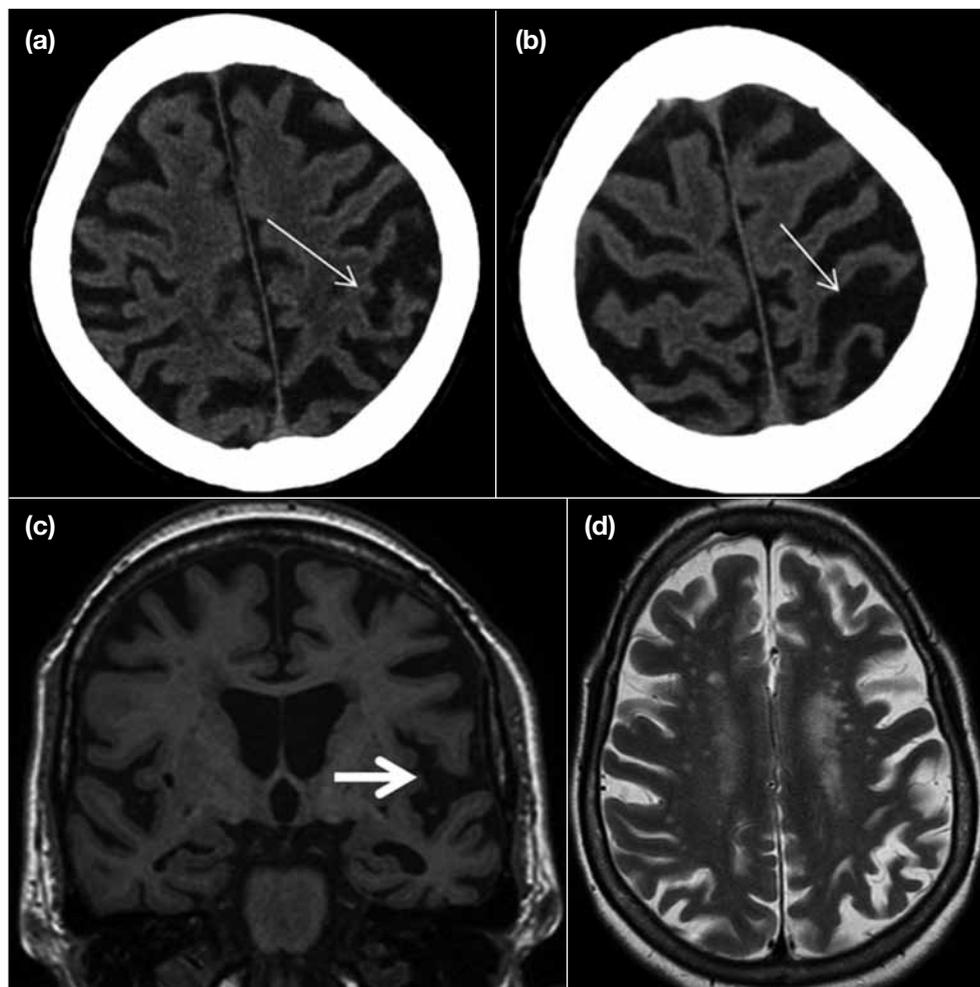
Computed tomography images of the brain of a patient with early-stage corticobasal degeneration showing (a and b) only subtle asymmetrical right perisylvian fissure atrophy (broad arrow), (c and d) right pericentral sulcus cerebral atrophy in the Rolandic region (narrow arrows). There is no evidence of a previous cerebrovascular accident to account for the cerebral atrophy.
